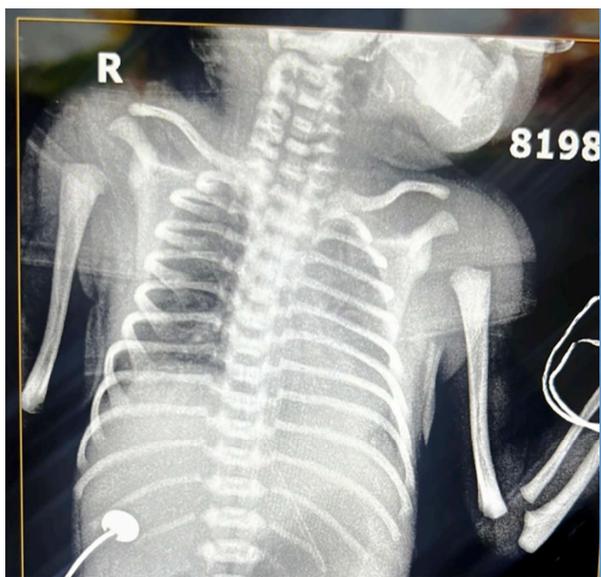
X-ray image showing a left upper-zone opacity
